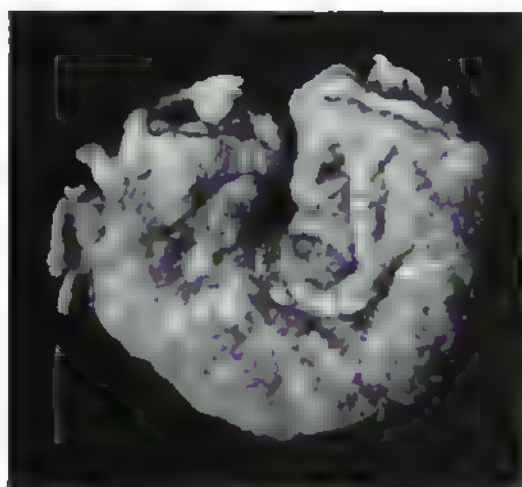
(Case No. A90,713; X-ray No. 24,338.) Pyloric end of stomach laid open, showing early carcinoma just within pyloric ring. (See skiagrams, Figs. 23 and 24.)
